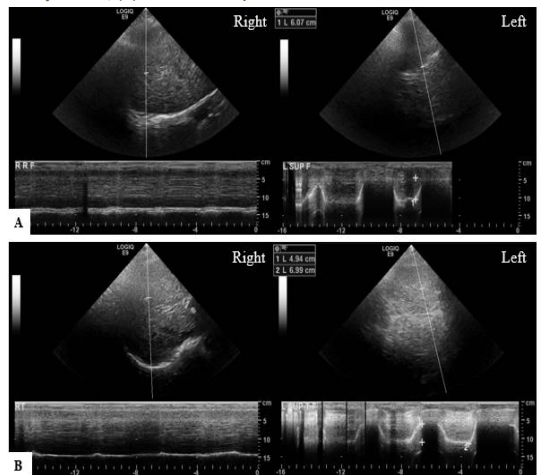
Diaphragm ultrasound study (A) first and (B) follow up study after 6 months. The right diaphragm showed complete paralysis while the left diaphragm movement was normal.
